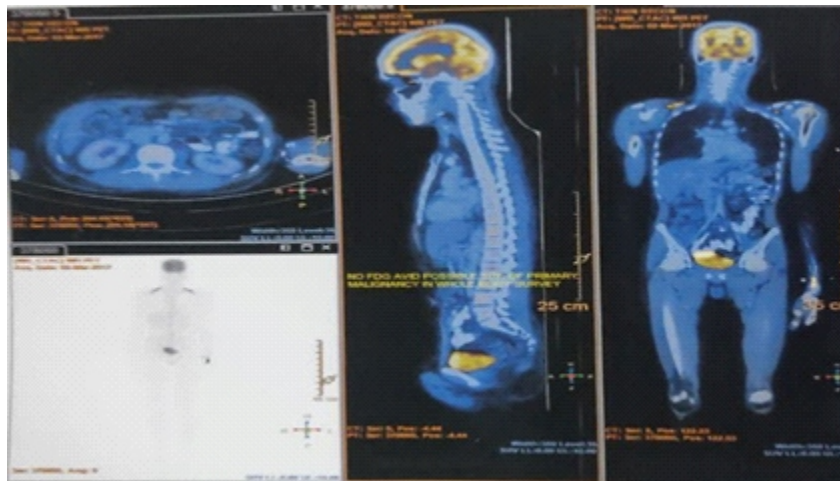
Whole body PET CT imaging
